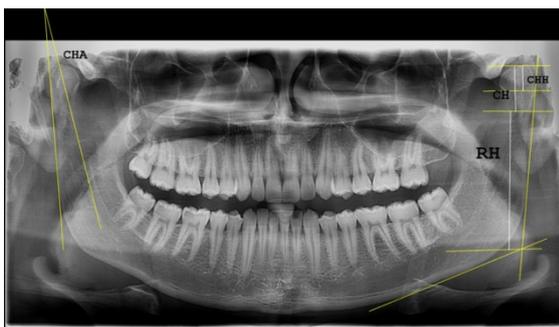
Panoramic radiograph shows CHH, CH, RH, and CHA
